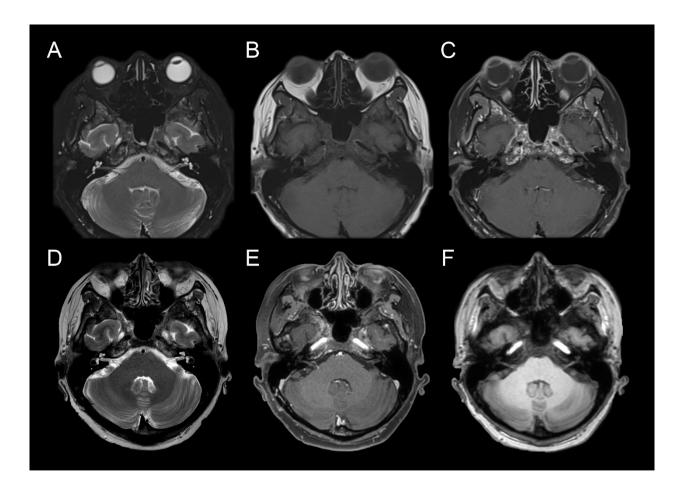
MRI of the brain axial view; comparing pre-treatment and post-treatment with systemic chemotherapy and dual-antiHER2. T2-weighted fat-suppressed image (A), T1-weighted image (B) and post-gadolinium T1-weighted fat-suppressed image (C) of pre-treatment showed an abnormal marrow signal, with enhancement of the clivus, petrous apex and bilateral greater sphenoid wings. After sessions of systemic treatment, no significant change in extension of the abnormal marrow signal at the base of the skull was seen, as shown in the T2-weighted fat-suppressed image (D), T1-weighted image (E) and post-gadolinium T1-weighted fat-suppressed image (F).
